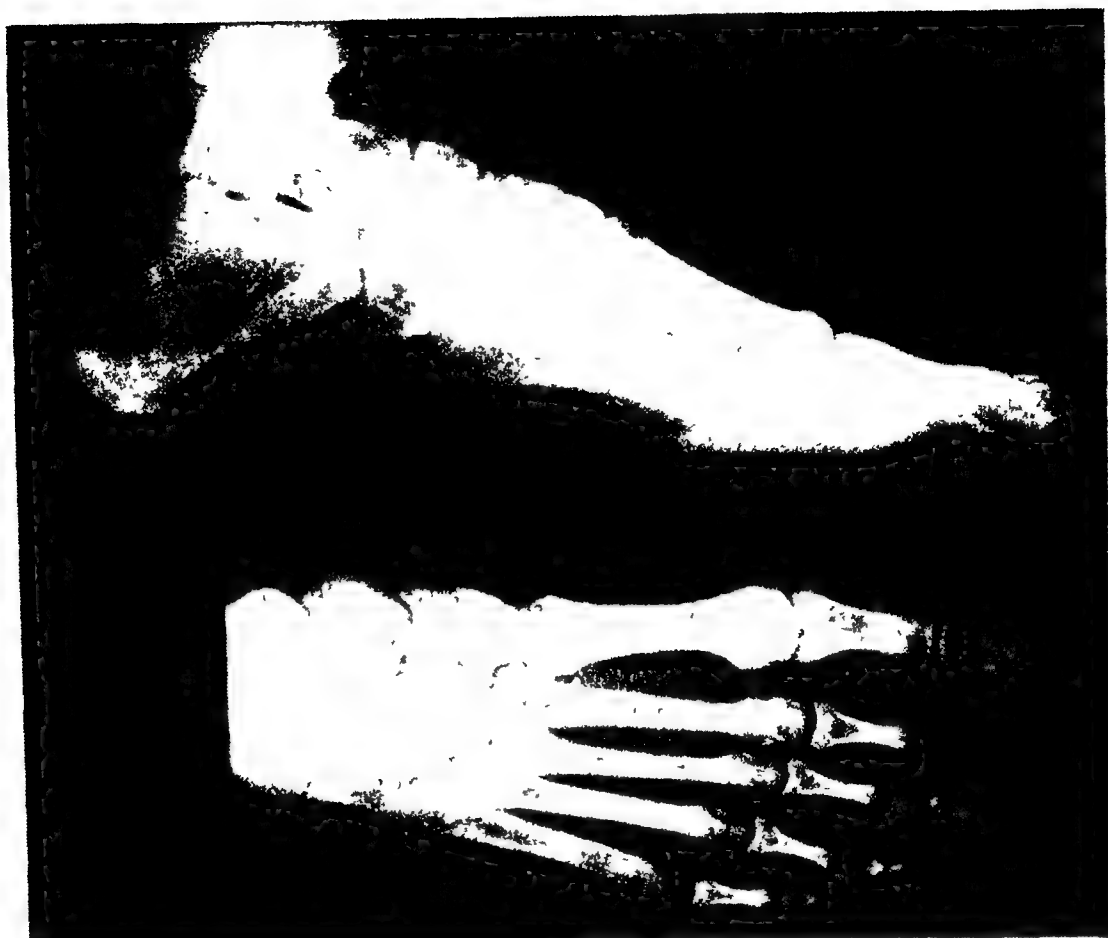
RADIOGRAPHIC FEATURES OF PES CAVUS. *Lateral view* (1) Pitch of calcaneus above 30 degrees (2) Fifth metatarsal at high pitch (3) Mid-tarsal joint line normal (4) Subtalar joint and sinus tarsi accentuated (5) Acute angle between subtalar joint and long axis of calcaneus.
